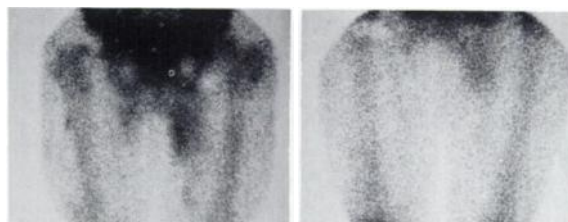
(left) is the 24-hr scintigram of Runner 8 who completed the 50-mile race. He experienced 4+ pain, and his scintigram is also rated 4+. It shows considerably increased uptake in the adductor muscles of the thighs. Figure 2 (right) is his repeat study, performed three days later. It shows continued uptake in the adductor muscles, although significantly less than in the 24-hr posttrace study.
